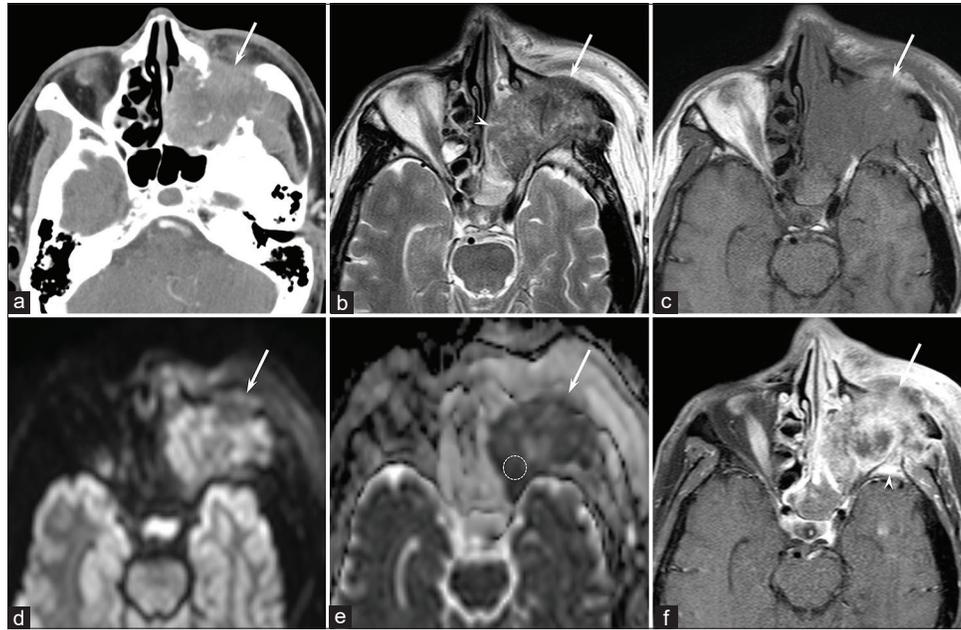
A 59-year-old man with HPV-positive SCC of the maxillary sinus. (a) Enhanced CT image shows a heterogeneously enhanced bulky mass (arrow) with destructive growth. (b) T2-weighted image (TR/TE, 4102/90 ms) shows a heterogeneously hypo- to hyperintense mass (arrow) with invasion of sphenoid sinus (arrowhead). (c) T1-weighted image (TR/TE, 630/9 ms) shows a hypointense mass (arrow). (d) Diffusion-weighted image (TR/TE/TI, 4954/72/170 ms) shows a heterogeneously hyperintense mass (arrow). (e) ADC map shows extremely low ADCmin ($0.483 \times 10^{-3} \text{ mm}^2/\text{s}$) and ADCmean ($0.769 \times 10^{-3} \text{ mm}^2/\text{s}$) (arrowhead). The dotted line shows the contours of region of interest placed on solid components. (f) Gadolinium-enhanced fat-suppressed T1-weighted image (TR/TE, 630/9 ms) shows a heterogeneously enhanced bulky mass with invasion of subcutaneous tissue (arrowhead) and sphenoid bone (arrowhead).
